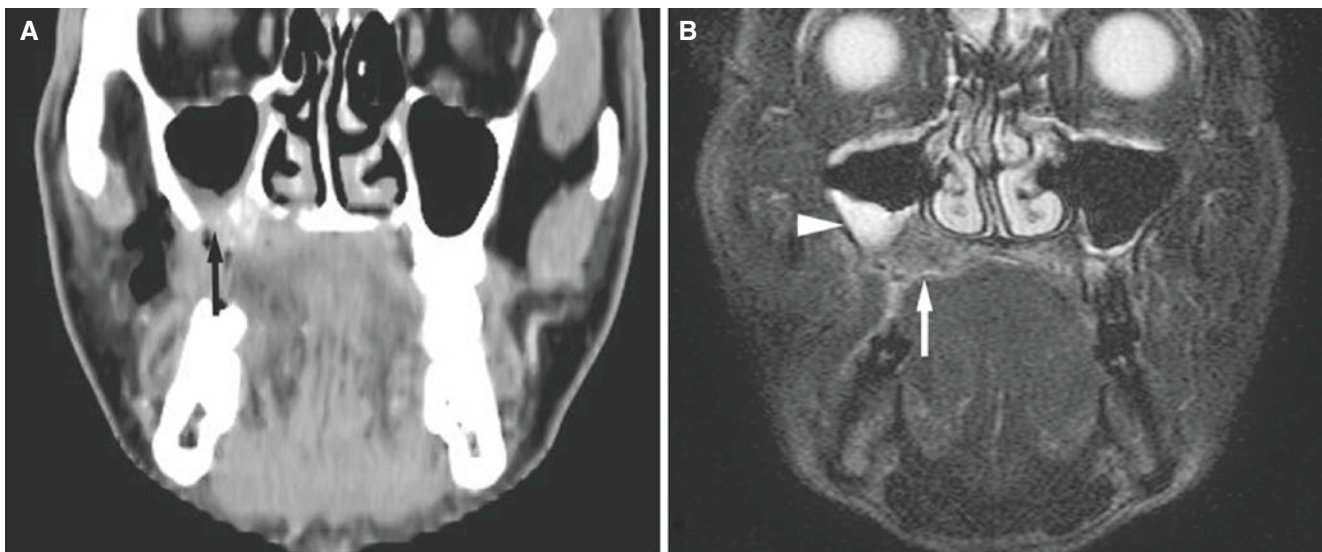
Squamous cell carcinoma, maxilla; 70-year-old female with some bleeding from tender soft-tissue mass of right gingival mucosa. (A) Coronal CT image shows destruction of maxillary sinus delineation (*arrow*) and soft-tissue mass. (B) Coronal T2-weighted fat-suppressed
